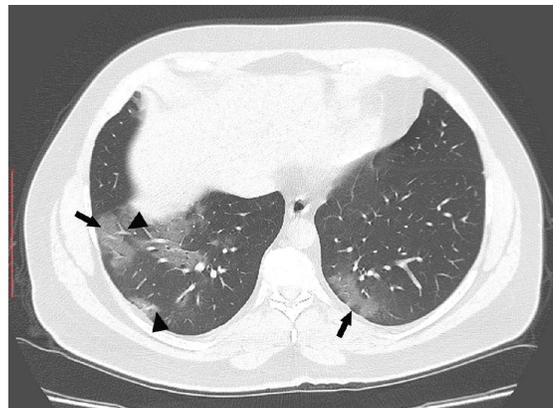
A case of COVID-19 pneumonia confirmed by RT-PCR. 45-year-old man, day 3 after symptom onset, with moderate severity criteria. A. Axial chest CT shows peripheral mixed consolidations (arrow) and GGO (arrowhead) in the middle lobe. B. Axial chest CT shows peripheral consolidations (arrow) surrounded by ground glass halo (arrowheads) in the left lower lobe.
